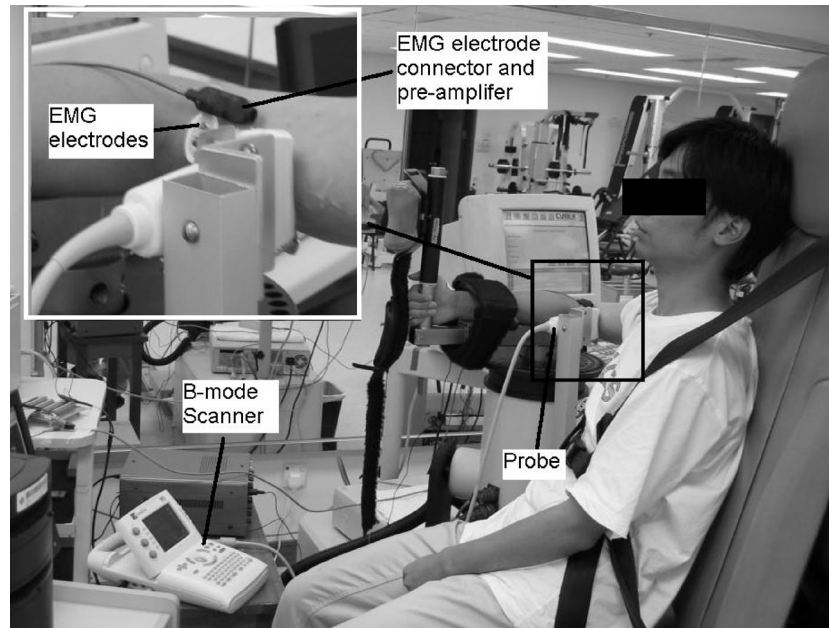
Experimental setup for the measurement of muscle isometric contraction with ultrasound imaging and EMG. The area labeled with the small rectangle is magnified in the upper-left corner.
